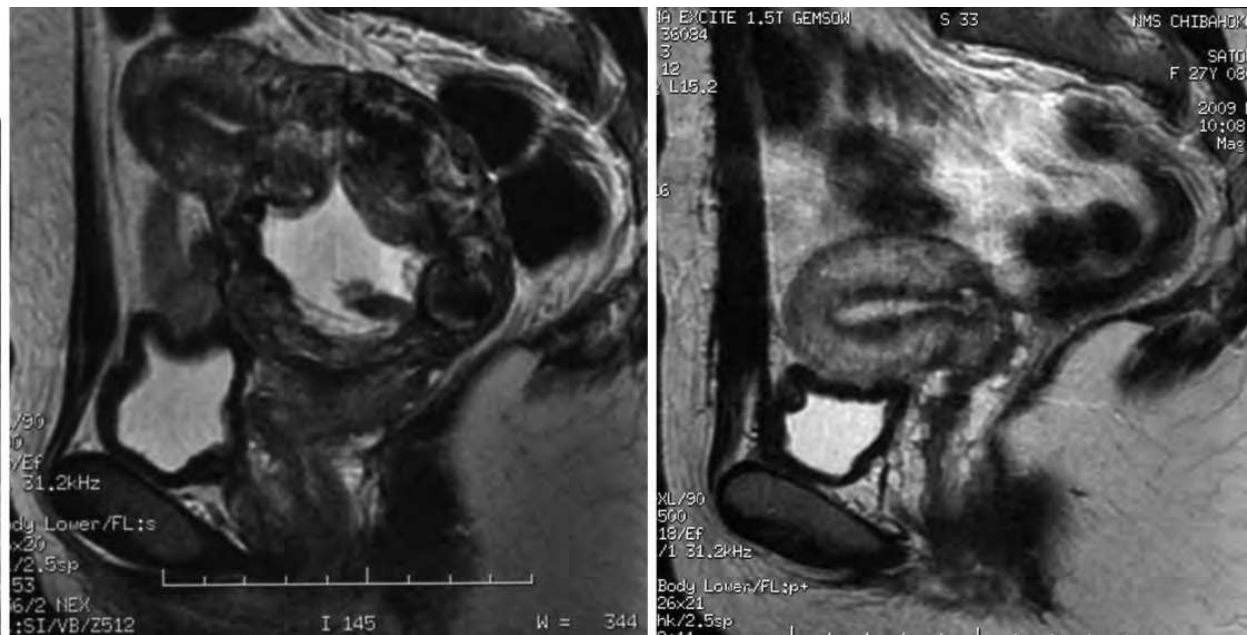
MRI immediately prior to surgery and one year and two months post-surgery
